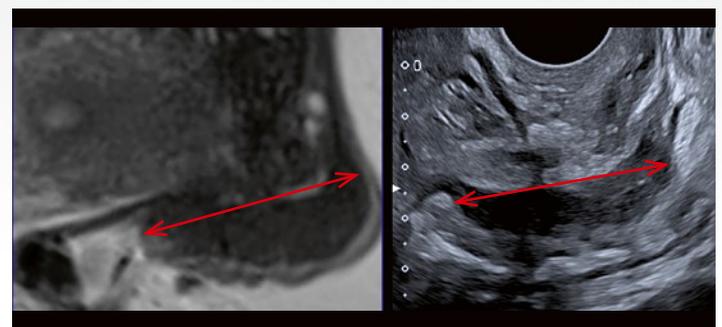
Rectal endometriosis nodule on MRI and ultrasound.
